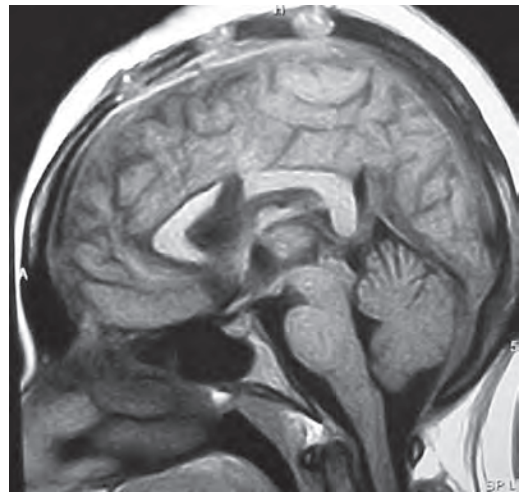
Post-operative MRI-mid sagittal plane of the same patient as in Figure 3A showing anterior callosotomy
